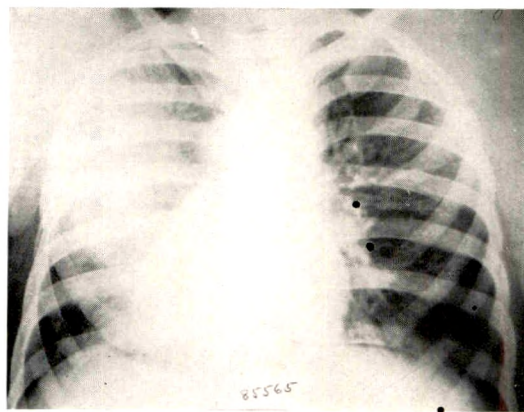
Traumatic pneumonia. Roentgen examination of same patient three days later showing development of massive pneumonic consolidation in left chest. The disease developed in the region receiving the trauma. Course and resolution were uneventful.
